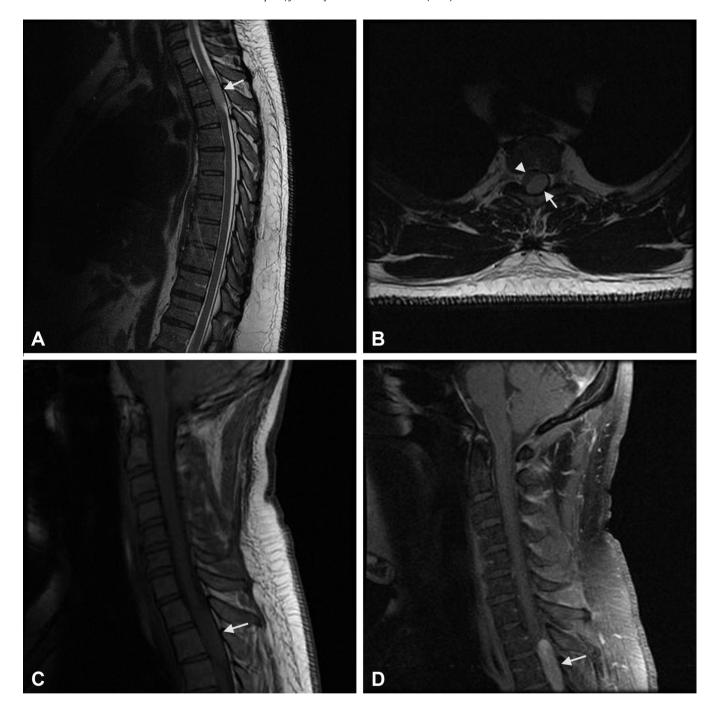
MRI of the thoracic and cervical spine at initial presentation. (A) Sagittal and (B) axial (at the T2 level) T2-weighted MRI of the thoracic spine, and sagittal T1-weighted imaging of the cervical spine (C) prior to and (D) following gadolinium injection are shown. A $3.6 \times 1 \times 1.2$ cm T1-isointense, T2-hyperintense, heterogeneously enhancing intradural extramedullary mass (arrow) at the T2 level is demonstrated, compressing the spinal cord (arrowhead) anterolaterally and to the right. Adjacent T2 hyperintensity within the cord is suggestive of edema.
